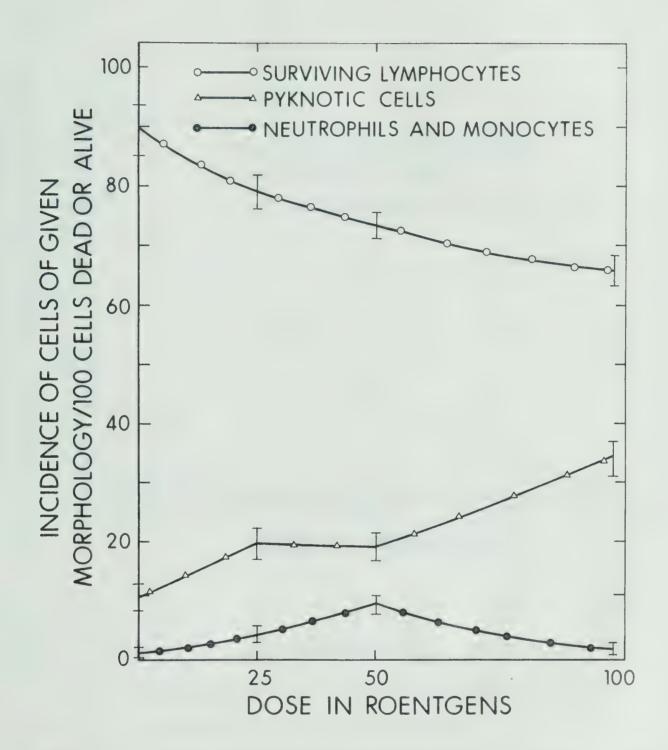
Effect of increasing single doses of X-rays, 0-100R, on incidence of surviving and pyknotic cells in culture (72 hr. post-irradiation).
